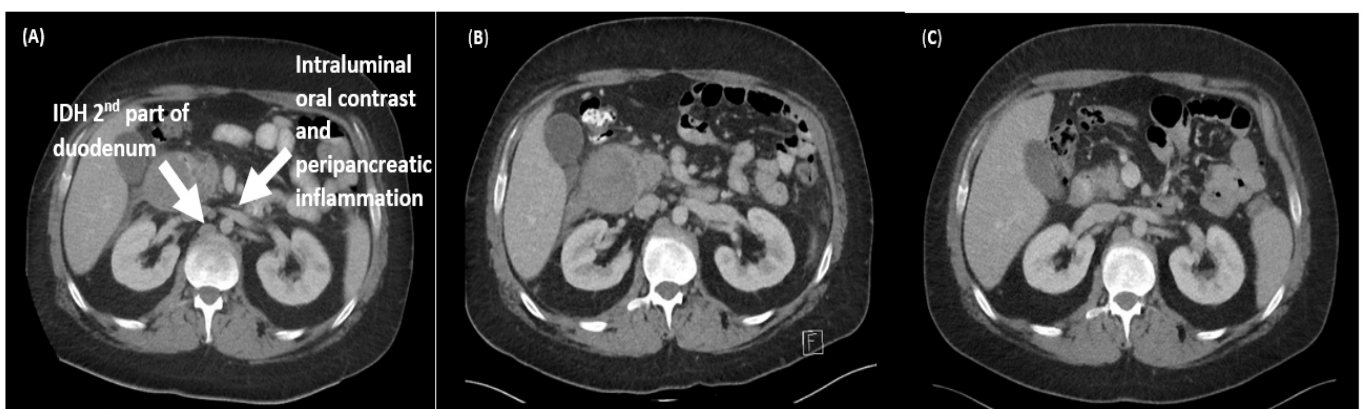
(A) Axial CT abdomen portal venous phase at presentation confirming acute IDH with associated pancreatitis compressing the 2nd part of the duodenum with oral contrast passing distally into jejunal loops. Inflammatory stranding of Gerota's fascia and free fluid in the subhepatic space (B) Interval inpatient CT abdomen with slight enlargement of IDH measuring 7.7cm in maximum dimension (C) Follow-up CT abdomen 2 months later confirming resolution of IDH
